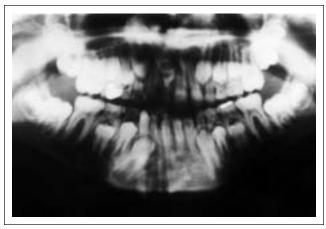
Panograph radiograph of same boy showing supernumerary tooth above primary right maxillary incisor.
